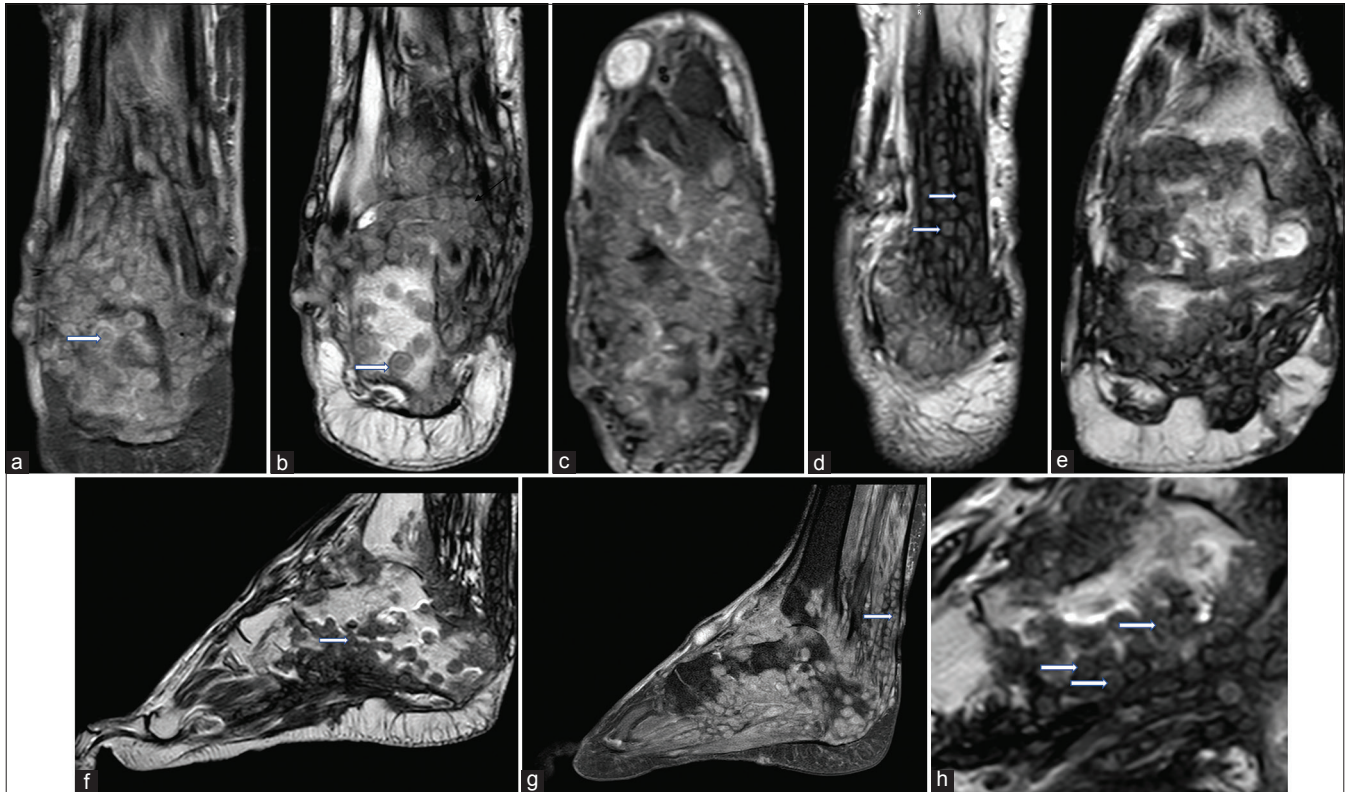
Magnetic resonance imaging (MRI) findings of foot with mycetoma (a) Short-tau inversion recovery (STIR) (b) Cor T2 (c) Cor STIR showing bone and joint involvement by mycetoma with multiple small, round to spherical hyperintense lesions (arrows). MRI findings: (d and e) different sections of Cor T2 showing achilles tendon studded with multiple small, round to spherical hyperintense lesions. Arrows showing “dot-in-circle” sign. MRI findings of left foot with mycetoma: (f) Sagittal T1 without contrast agent shows multiple isointense lesions containing some central hypointense dots and surrounded by hypointense tissue (arrow), and (g) short-tau inversion recovery images showing central hypointense dot, resulting in the “dot-in-circle” sign (arrows). The surrounding hyperintense inflammatory soft-tissue changes are also seen. (h) Magnified view of “dot-in-circle” sign. Some of the lesions are showing central hypointense dot surrounded by hyperintense inflammatory tissue.
